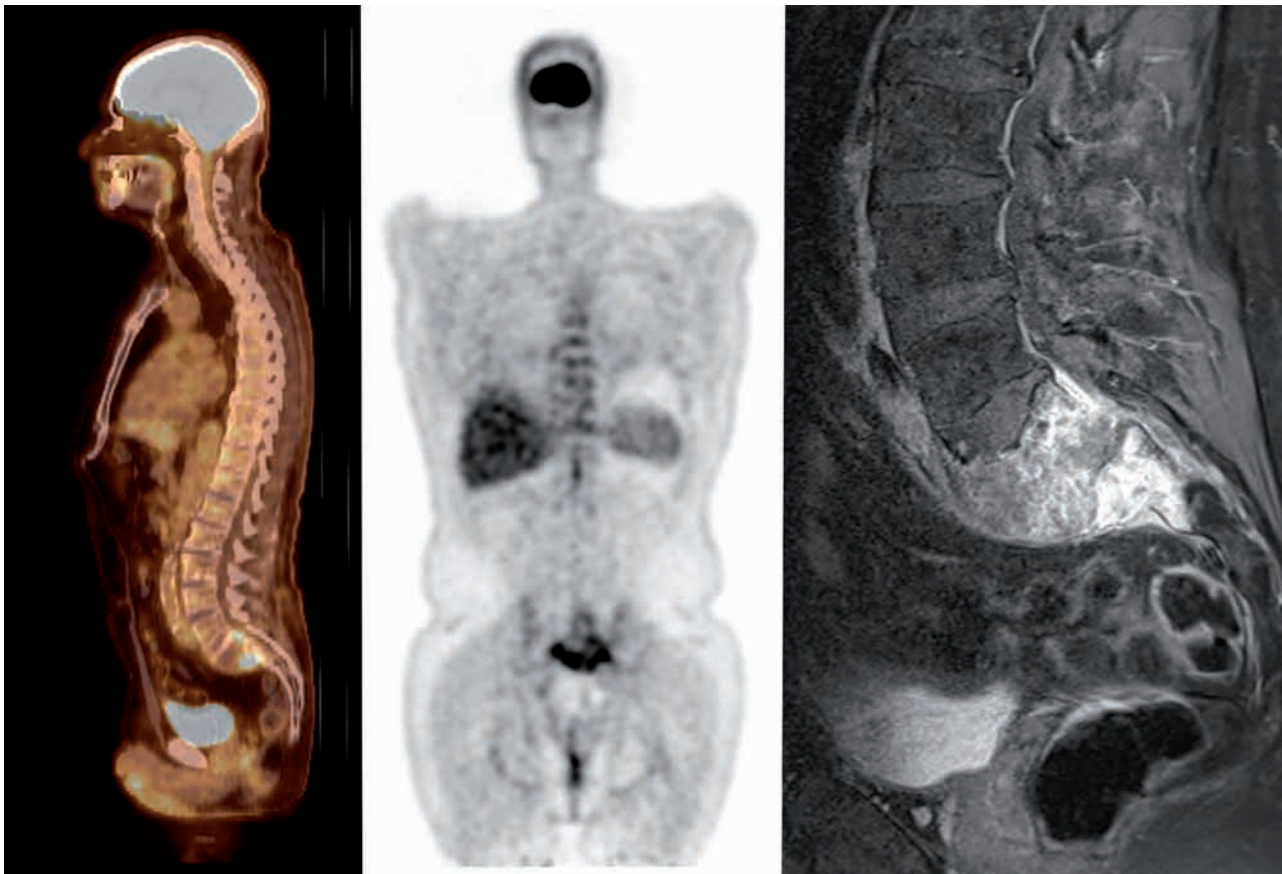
Pet-CT and MRI showing the tumoral bone lesion S1-S2, with perisacral extension
